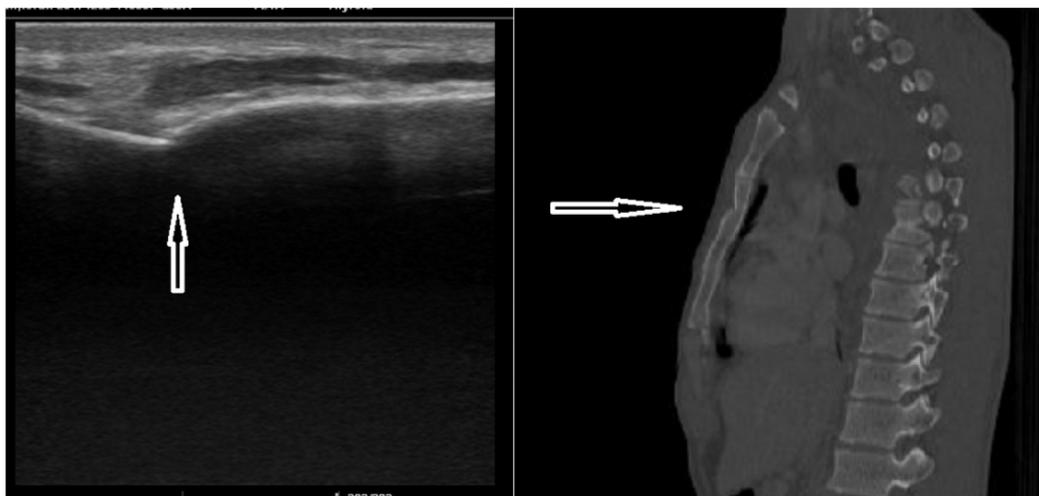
Twenty-three year old male patient admitted to emergency department with trauma in his head and thorax which occurred traffic accident. Sternum fracture was determined by thorax ultrasonography and thorax computerized tomography.
